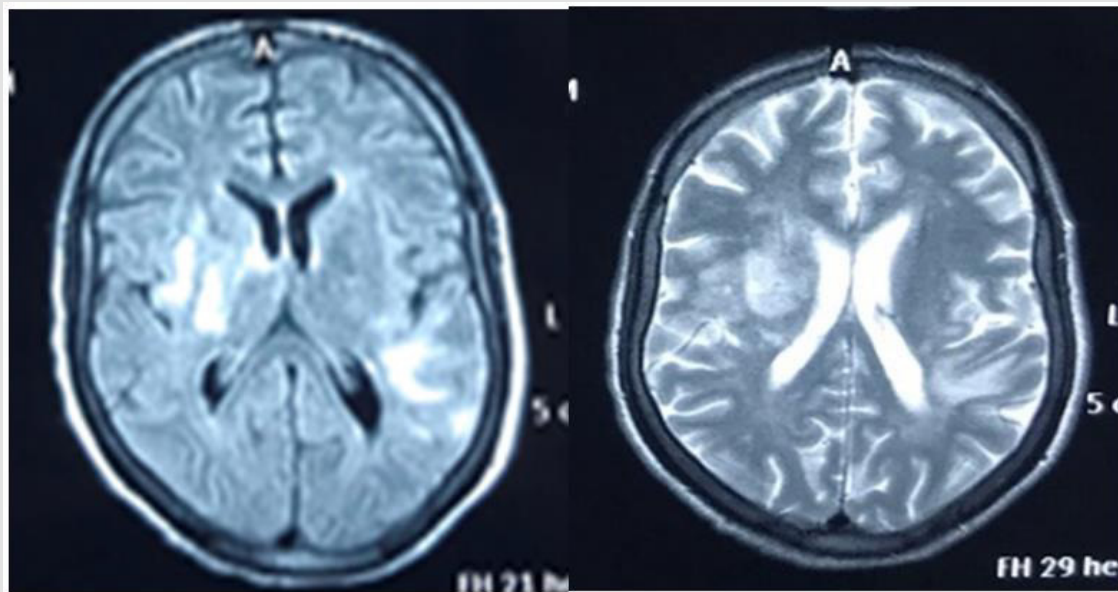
Magnetic resonance imaging brain showing focal hyperintense lesion (FLAIR& T2) in cerebral cortex and subcortical white matter indicating demyelination of brain in the first episode (July 2018).
